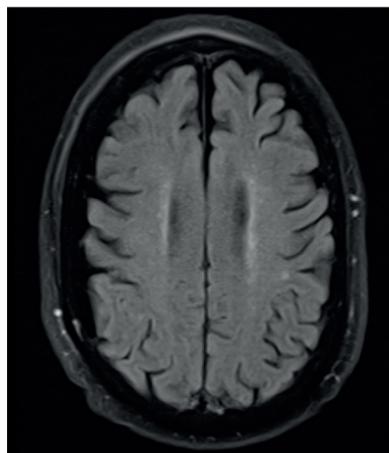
Fluid attenuated inversion recovery (FLAIR) sequence on the second day after trauma, showing no relevant abnormalities
